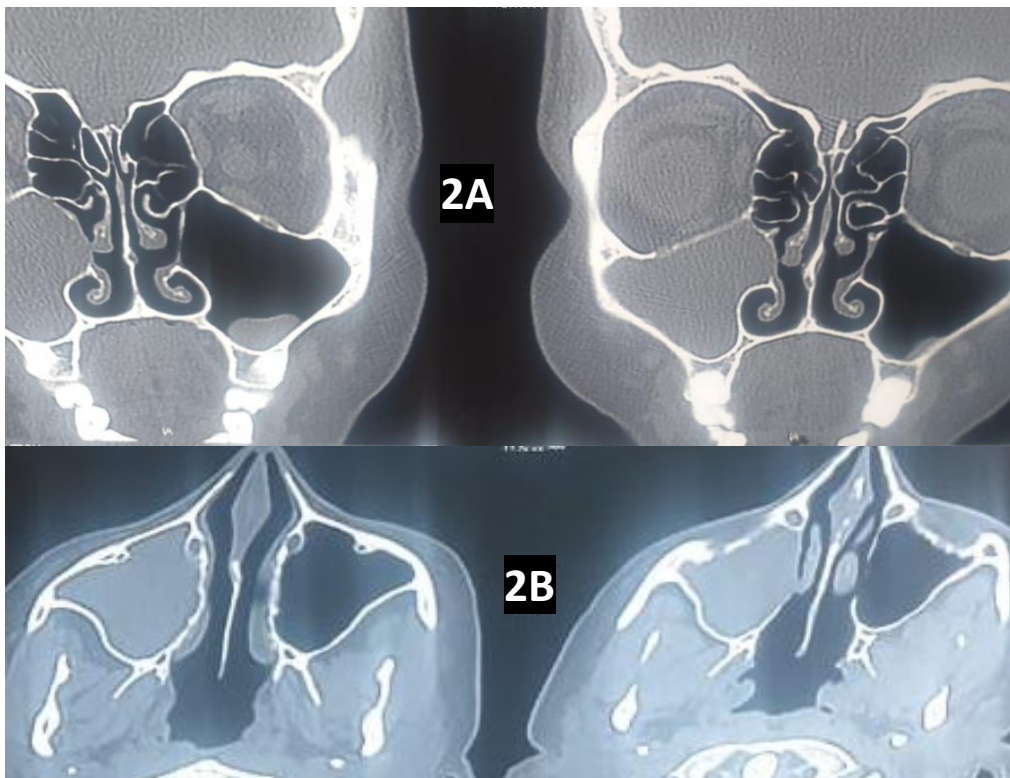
CT-Coronal view (2A) and Axial view (2B) : showing well-marginated, expansile, soft tissue density in the right maxillary sinus passing through a widened maxillary sinus ostium
